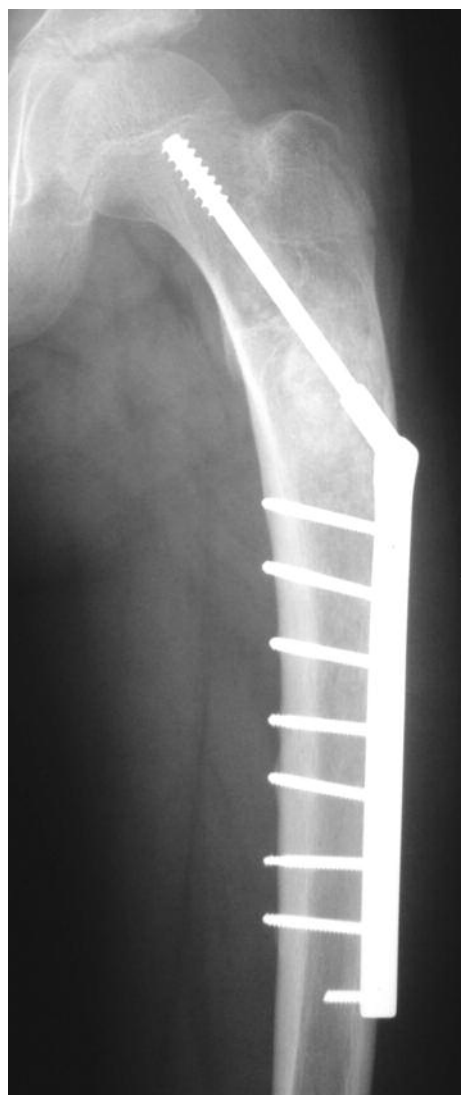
Radiograph 3 months after surgery
